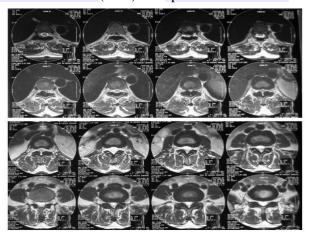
Axial T2-weighted MRI showing hypointense OLF compressing the spinal cord without intramedullary signal abnormality.
